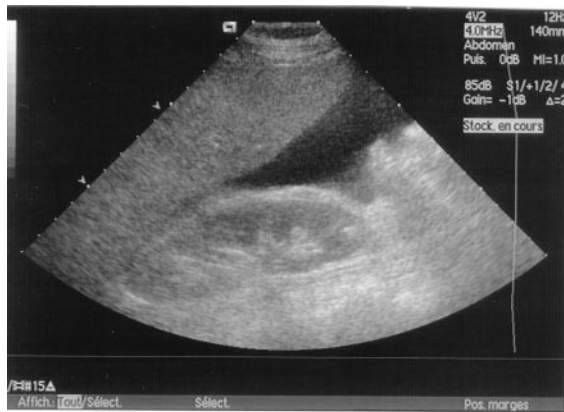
Abdominal sonography demonstrating a marked ascites with fundamental mode (top) and harmonic imaging (bottom). The second appears clearer than the first.
